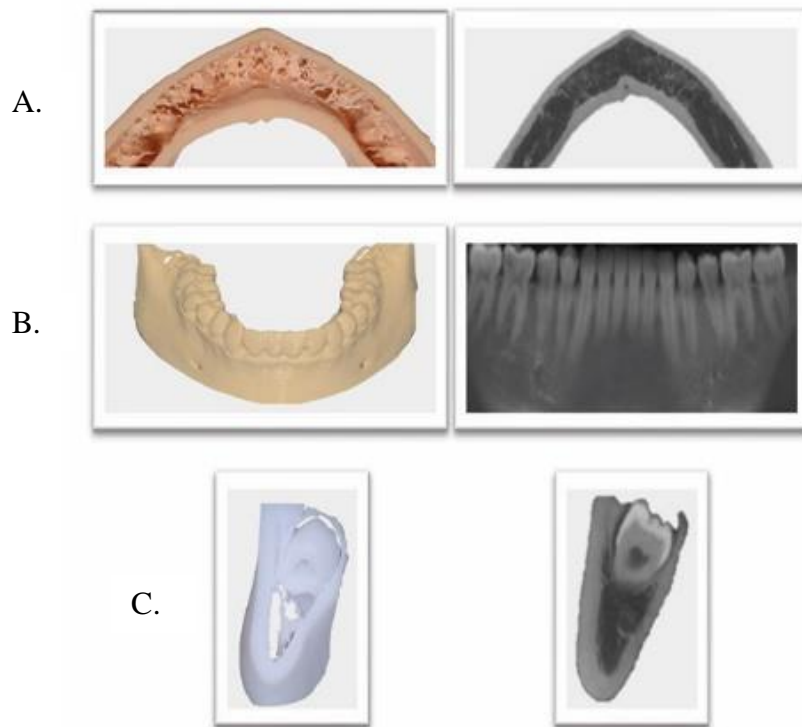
Three-dimensional printed model corresponding to the CBCT image. A, inferior view, B. frontal view. C, posterior view
